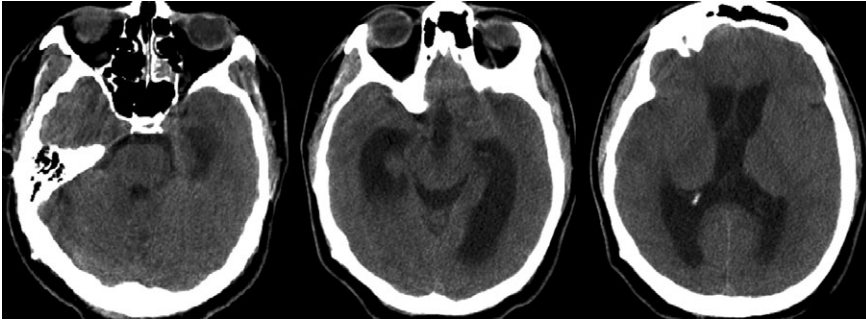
CT scan of the head demonstrating dilation of the ventricular system: bilateral lateral ventricles and third ventricle. Of significance is the out-of-proportion small fourth ventricle indicating an obstruction within the ventricular system between the third and fourth ventricles.
